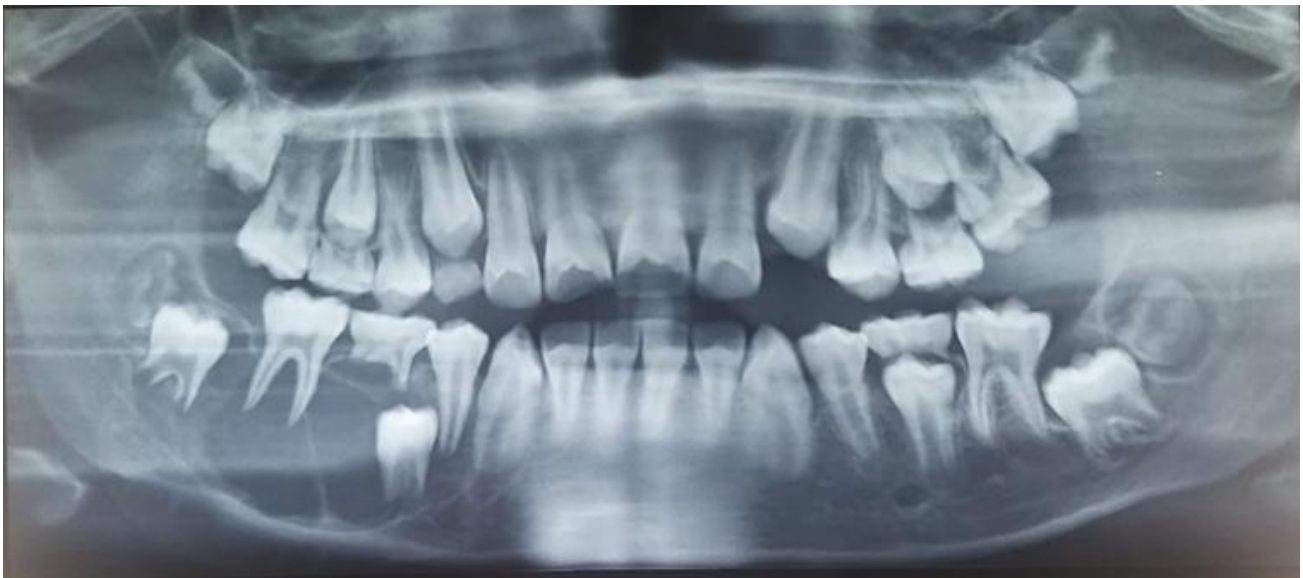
Panoramic radiograph of Case 1, lesion visible on the right side of the mandible. The lesion is quite large, covering the distal tooth 43 to the posterior mandible. (personal archive)²⁴
